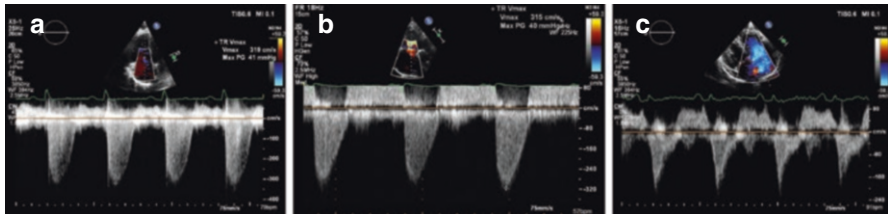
Optimal visualization of TR jet on CW Doppler in a patient with mild (a), moderate (b) and severe (c) TR. Observe the shape of the TR jet envelope
